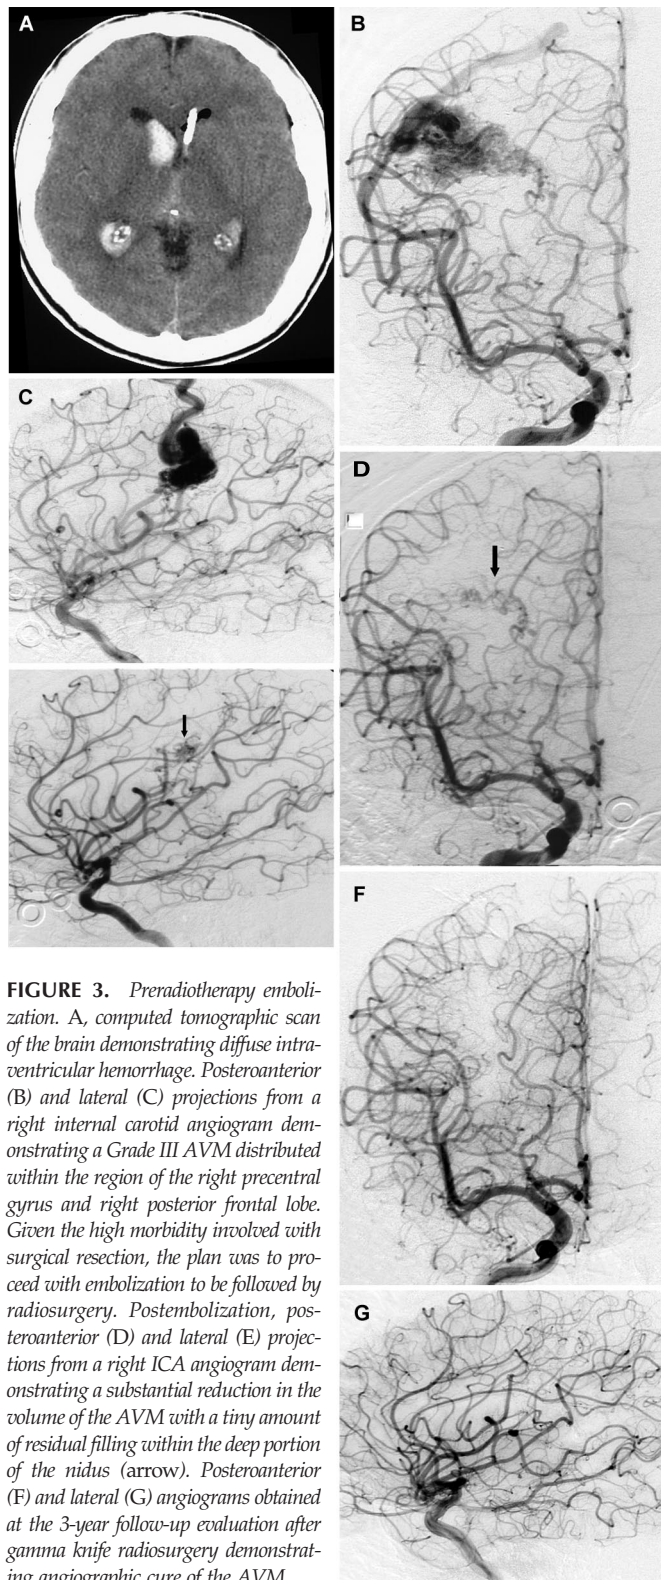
Preradiotherapy embolization. A, computed tomographic scan of the brain demonstrating diffuse intraventricular hemorrhage. Posteroanterior (B) and lateral (C) projections from a right internal carotid angiogram demonstrating a Grade III AVM distributed within the region of the right precentral gyrus and right posterior frontal lobe. Given the high morbidity involved with surgical resection, the plan was to proceed with embolization to be followed by radiosurgery. Postembolization, posteroanterior (D) and lateral (E) projections from a right ICA angiogram demonstrating a substantial reduction in the volume of the AVM with a tiny amount of residual filling within the deep portion of the nidus (arrow). Posteroanterior (F) and lateral (G) angiograms obtained at the 3-year follow-up evaluation after gamma knife radiosurgery demonstrating angiographic cure of the AVM.
